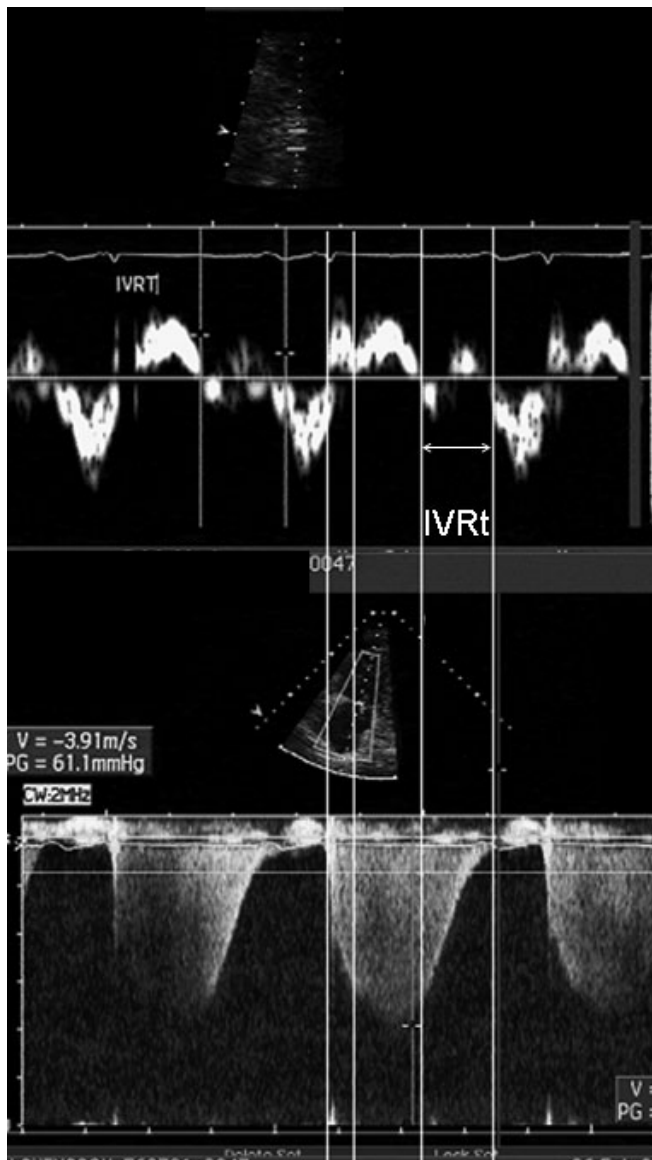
Simultaneously superimposed pulsed Doppler tissue imaging and continuous Doppler echocardiography. The onset of relaxation is dependent on the time for regurgitation in the tricuspid valve. In this case, the gradient between right ventricular and right atrial pressure drop was 65 mmHg. Note also the impaired filling time for the right ventricle.
